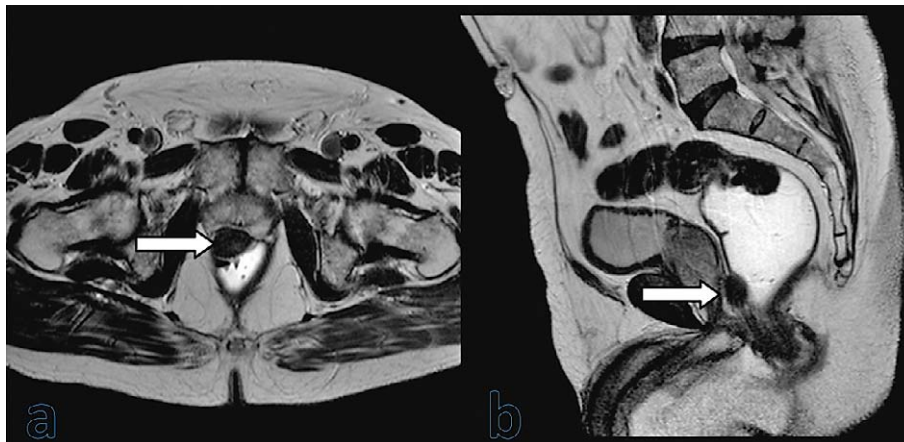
T2-weighted axial (a) and sagittal (b) plane, low signal intensity mass in the rectal wall (shown by arrow)
